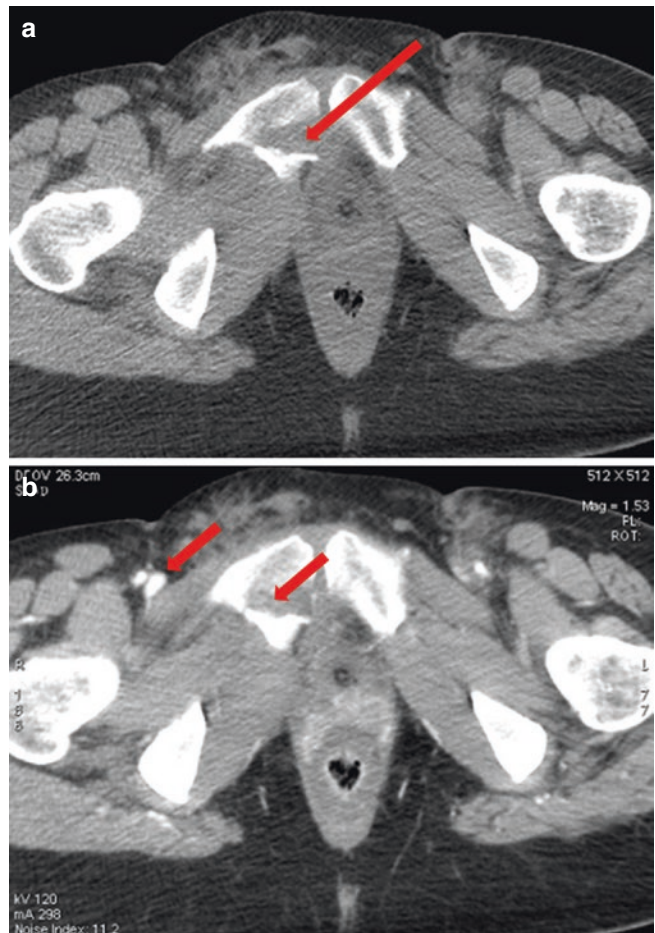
Unenhanced (a) and post-contrast arterial phase (b) axial CT image. Hyperdense area close to the right ischio-pubic branche (long arrow) showing an attenuation higher than that of the iliac arteries (short arrows) (b) but equal in both unenhanced (a) and arterial (b) phases, corresponding to a bone fragment
